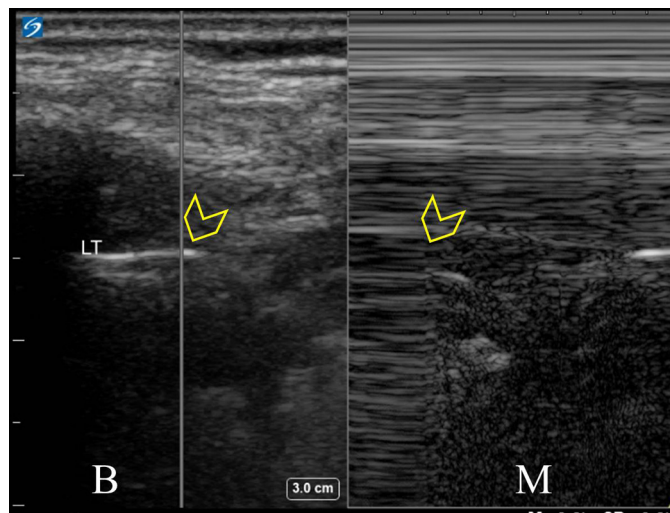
Ultrasound scan for mapping of the left pneumothorax. The lung point sign (arrow head) showed in B-mode (B) and in M-mode (M). (Sonographic study was performed by Dr. Ashraf F Hefny, Department of Surgery, Al Rahba Hospital, Abu Dhabi, UAE)
